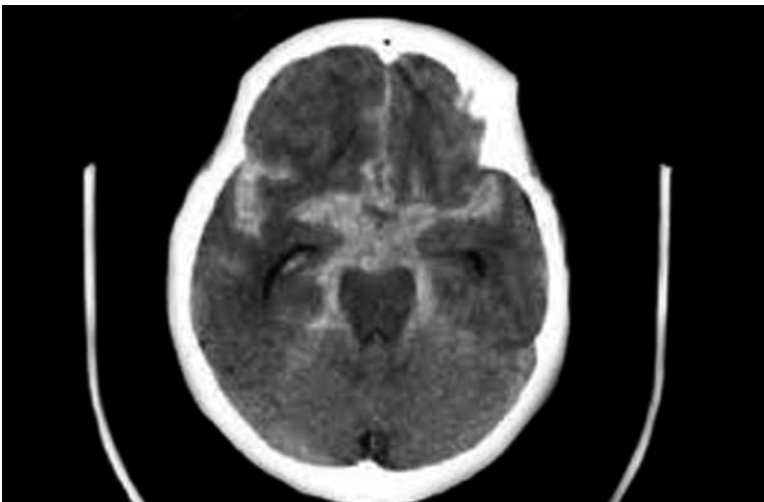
Star Shaped, "The Lone Star Flag" Blood (bright white) is seen in the subarachnoid space on noncontrast CT
